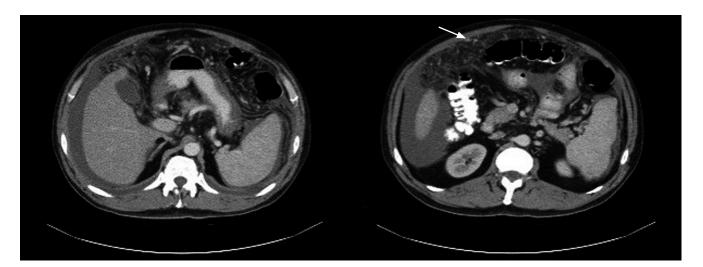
Contrast-enhanced CT scan of the abdomen. Small size liver, thickening and multiple small nodules in the peritoneum enhanced by the contrast medium.
